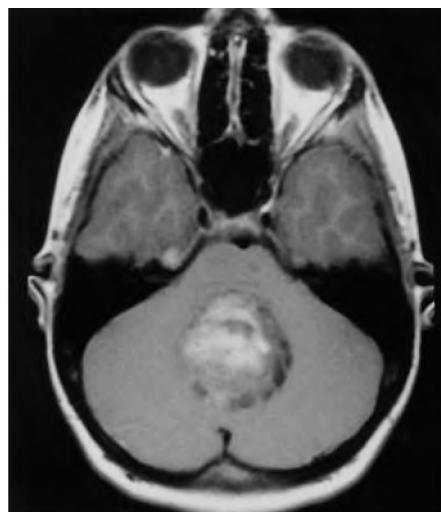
Case 6. A 6-year-old girl with a split vermis who developed mutism postoperatively. A preoperative axial T<sub>1</sub>-weighted magnetic resonance image with gadolinium enhancement shows a midline cystic lesion involving the vermis.
